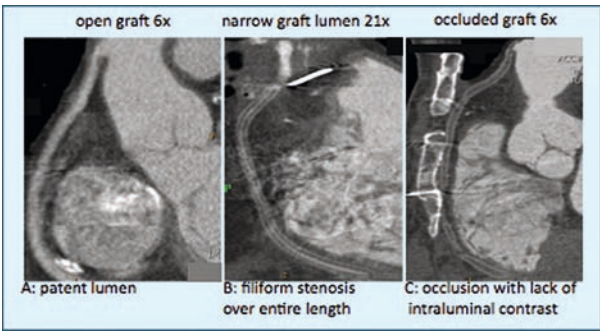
Examples of typical CT results obtained at six months of open graft, narrow lumen graft and occluded graft
